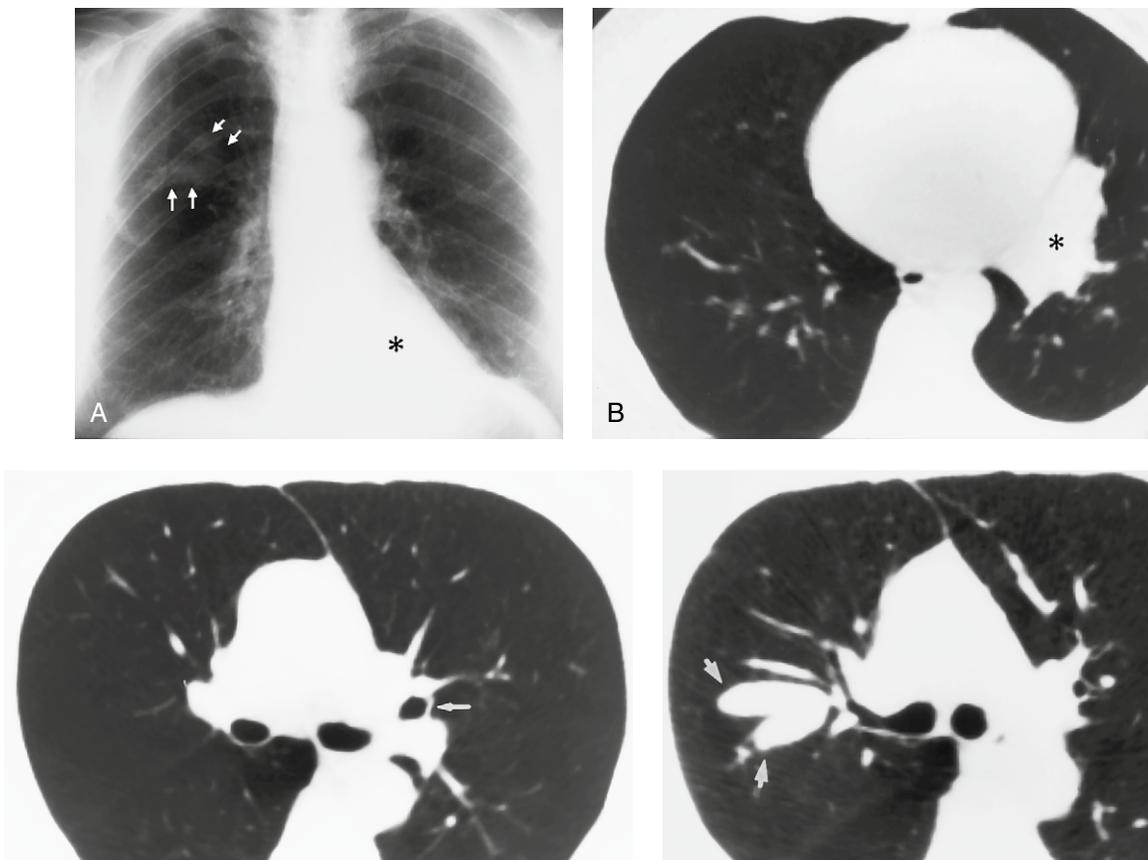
Allergic bronchopulmonary aspergillosis. (A) Posteroanterior (PA) chest radiograph of a 65-year-old woman reveals abnormal opacity in the left retrocardiac area (*asterisk*) which causes non-visualization of the medial portion of the left hemidiaphragm and the retrocardiac descending aorta. Note the subtle “v-shaped” opacity within the right upper lobe (*arrows*). (B) Chest CT image (lung window) through the lower thorax shows that the retrocardiac opacity in (A) represents airless consolidation within the anteromedial basal segment of the left lower lobe (*asterisk*). (C) Chest CT image (lung window) reveals central bronchiectasis involving apical posterior bronchus in left upper lobe (*arrow*). (D) Chest CT image (lung window) demonstrates a “v-shaped” opacity (*arrows*) representing impacted mucus within ectatic bronchi in the posterior segment of the right upper lobe, corresponding to that seen in (A).
